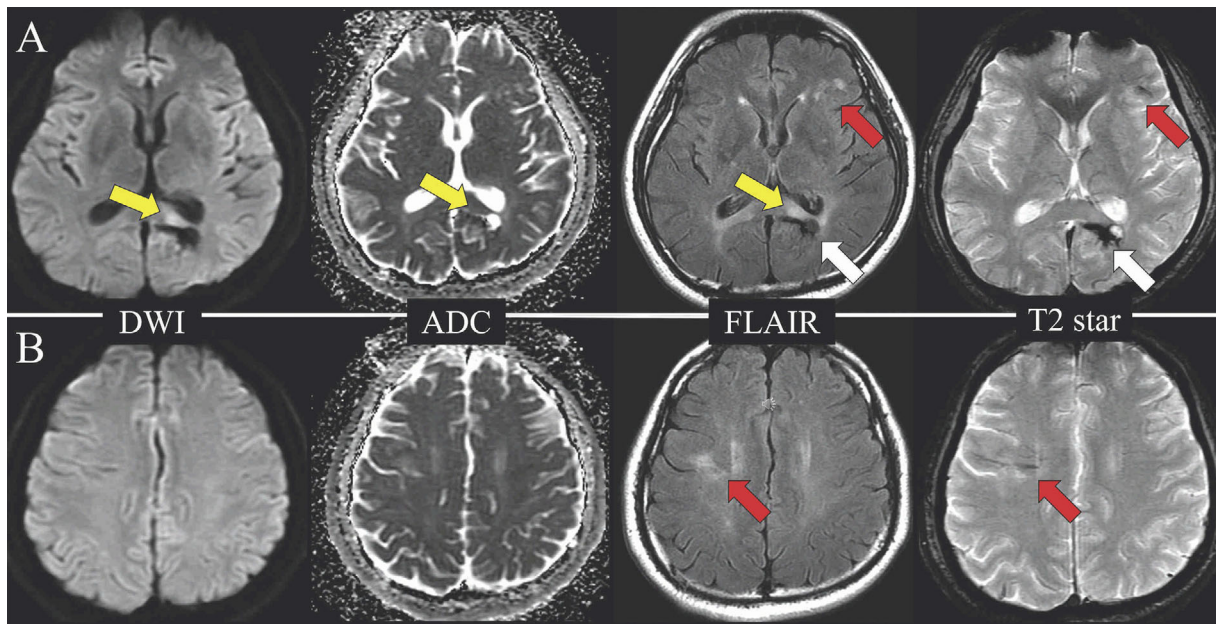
Head MRI findings on admission. Upper (A) and lower panels (B) show axial slices at the level of the foramen of Monro and centrum semiovale, respectively. (A) Diffusion-weighted imaging (DWI) demonstrates a high signal intensity in the left deep white matter near the splenium of the corpus callosum; without changes in the apparent diffusion coefficient (ADC). Fluid-attenuated inversion recovery (FLAIR) MRI shows a high signal intensity in the same area, suggesting subacute phase or later cerebral infarction (yellow arrows). FLAIR MRI also shows a low intensity area near the cerebral infarction with a low intensity on T2 star-weighted imaging, indicating old hemorrhage (white arrows). (A, B) FLAIR MRI shows multiple high intensity areas in the left frontal lobe and right deep white matter with or without low intensity on T2 star-weighted imaging, indicating old infarction or hemorrhage, respectively (red arrows).
